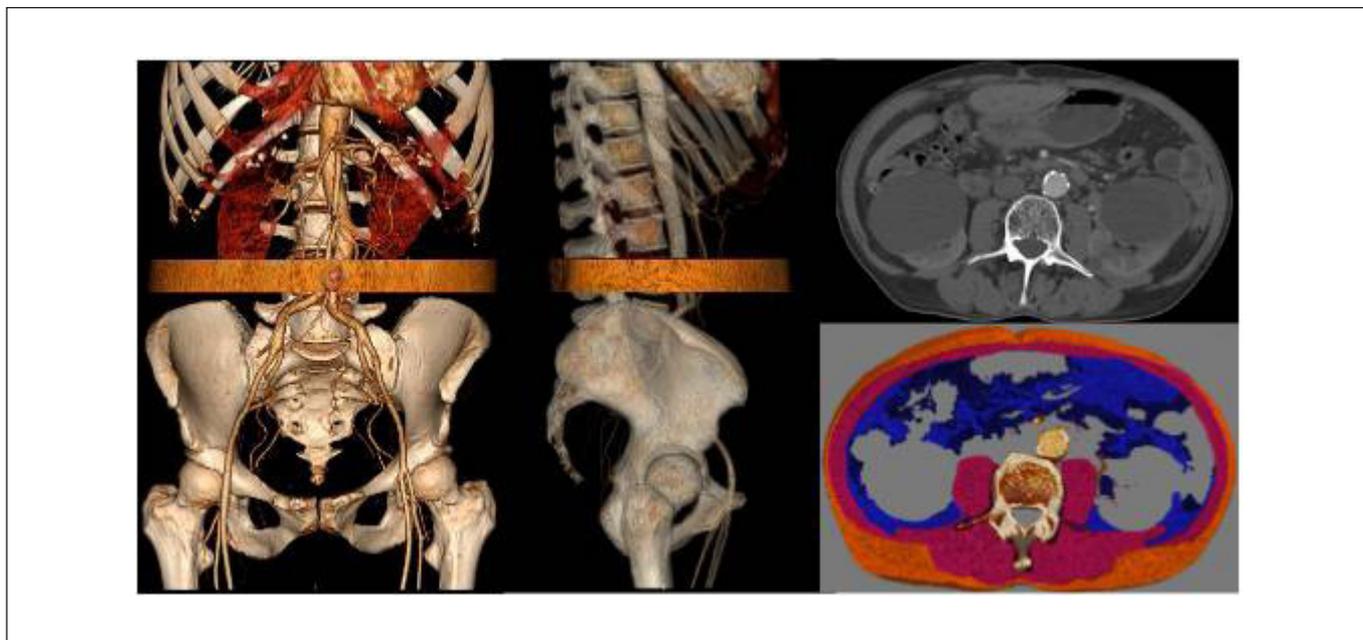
Example of axial CT slice at L3 and L4 for assessment of body composition using software.
